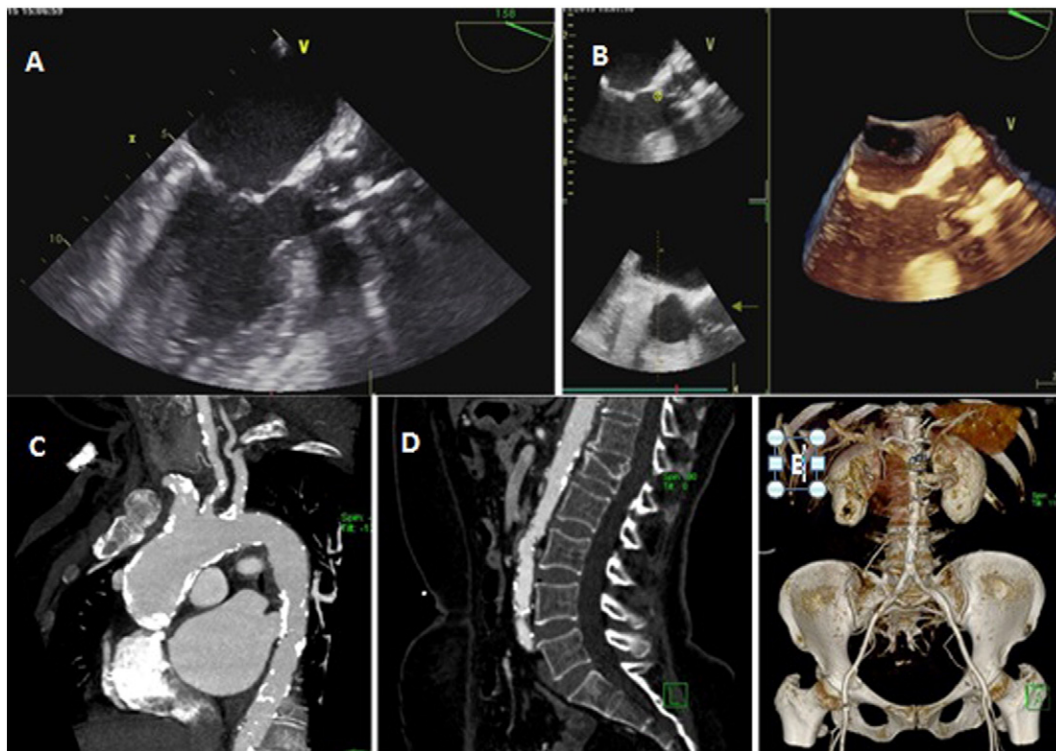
A, B: Transesophageal echocardiography (TEE) and 3D reconstruction view showing diffuse protruding plaques in the ascending aorta and sinuses valsalva. C, D, E: Multislice cardiac computed tomography and 3D multislice cardiac computed tomography reconstruction showing porcelain aorta, heavily calcified atherosclerotic involvement of entire aorta, iliac and femoral arteries.
